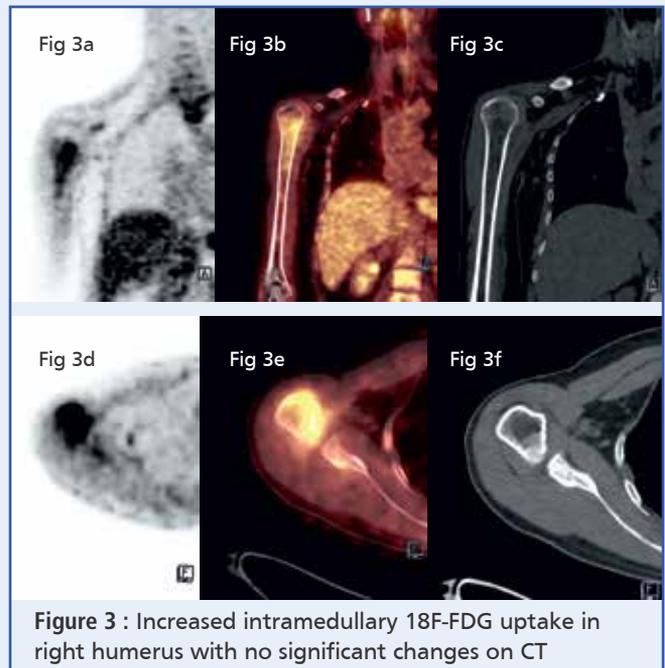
Increased intramedullary 18F-FDG uptake in right humerus with no significant changes on CT
